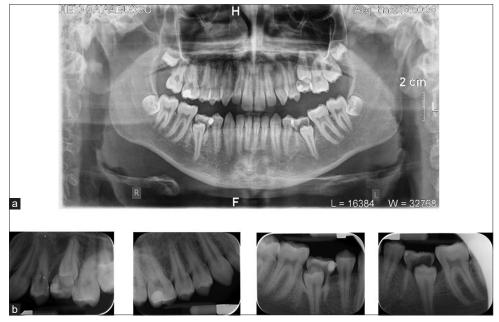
(a and b) Panoramic examination confirmed the presence of all 32 permanent teeth. Lower 2nd premolars and upper left second premolar were impacted, as also the upper left 2<sup>nd</sup> molar. The third molar position seemed unfavorable. Periapical films confirmed the panoramic findings for over-retained deciduous molars with unfavorable root resorption pattern and bone recession in the area.
